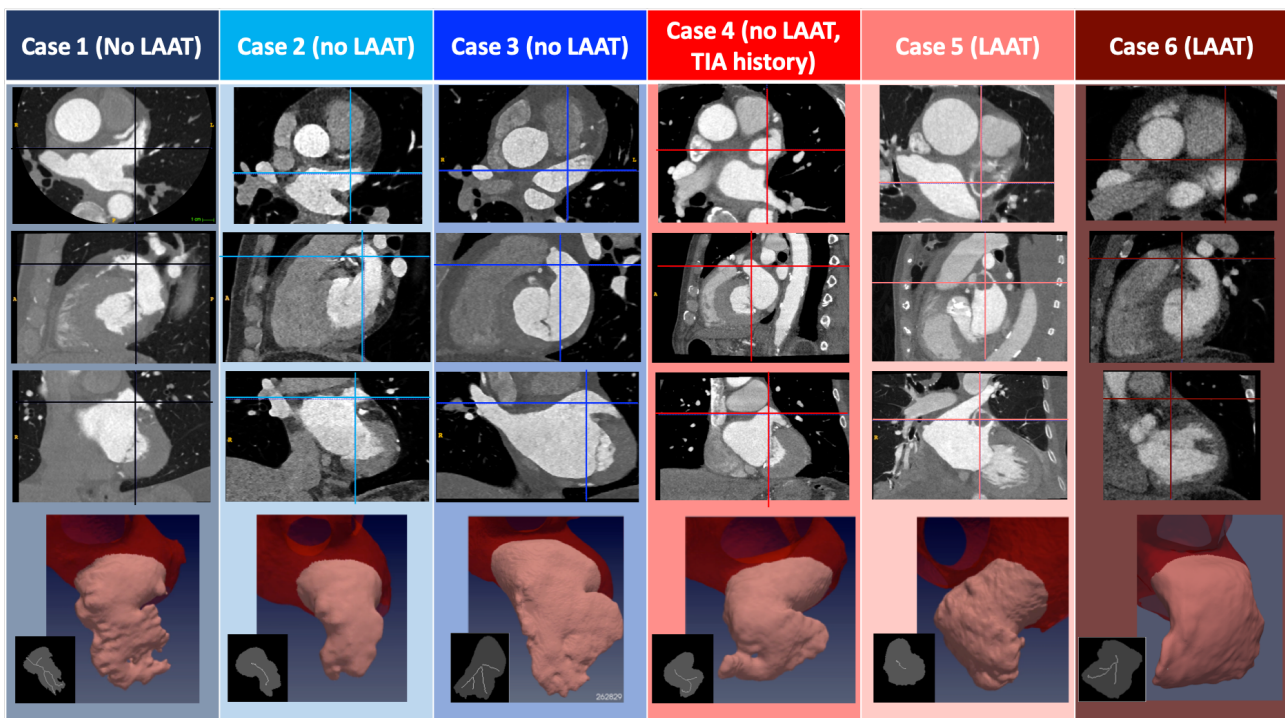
Anatomical Features of Patient-Specific Subjects. The three first rows display CT images corresponding to the $N = 6$ subjects studied. The images represent, from top to bottom, axial, sagittal and coronal plane sections showing the left atrium, and including LAA thrombi if present (patients 5 and 6). In each panel, the intersections with the other two view planes are represented with a vertical and a horizontal line. The bottom row displays a 3D rendering of the segmented LAA for each subject, and an inset showing its plane projection (gray) and the branches that define the LAA lobes (white). Data are shown at an instant corresponding to 50% of the R-R interval.
